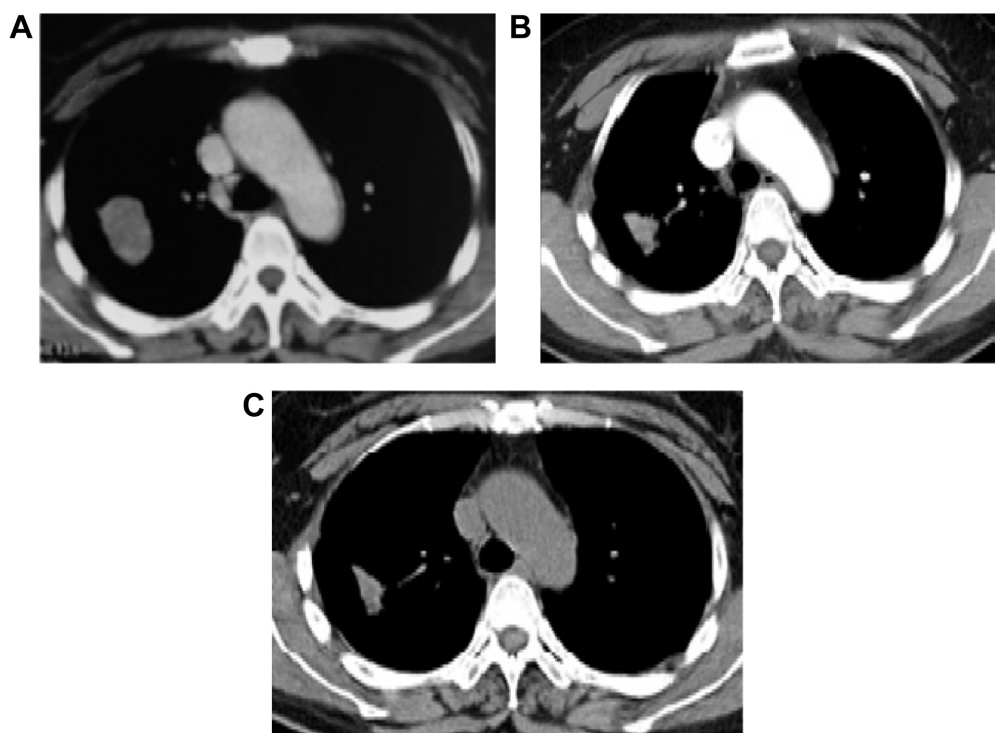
The computed tomography scan at diagnosis with a 3.9 cm bean-shaped tumor in the upper lobe of right lung (A). The lesion had significant reduction in tumor size 1 month later (B), and remained stable for 31 months with oral icotinib therapy (C).
